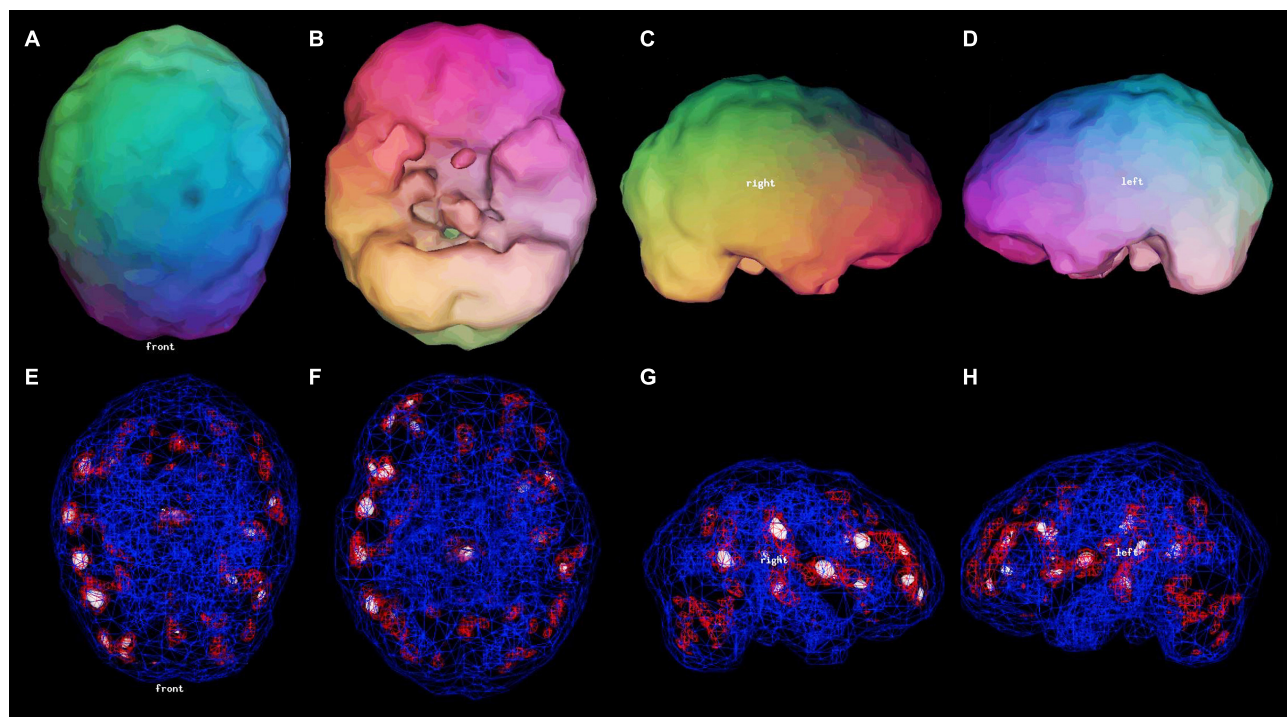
The second SPECT scan of Patient C shown as it was originally viewed after processing with the Picker Odyssey software. (A–D) 3-D representation of the scan data is shown. The surface is set at 60% of brain maximum. Areas which fall below 55% are represented as indentations or holes depending on how far below 55% the activity falls. (A) Vertex view, (B) Underside view, (C) Right Lateral, (D) Left Lateral. (E–H) A wireframe brain representation is shown, wherein the areas of brain with activity at 85% of maximum or greater are shown in red and areas of 92% or greater are shown in white. (E) Vertex view, (F) Underside view, (G) Right Lateral, (H) Left Lateral. The details of the SPECT scan are much harder to appreciate without the tomograms. The extent of the diffuse cortical increased perfusion is much more difficult to appreciate with this post-processing software. The extent of the co-existing areas of hypoperfusion in the parietal cortices are not evident with this post-processing software.
